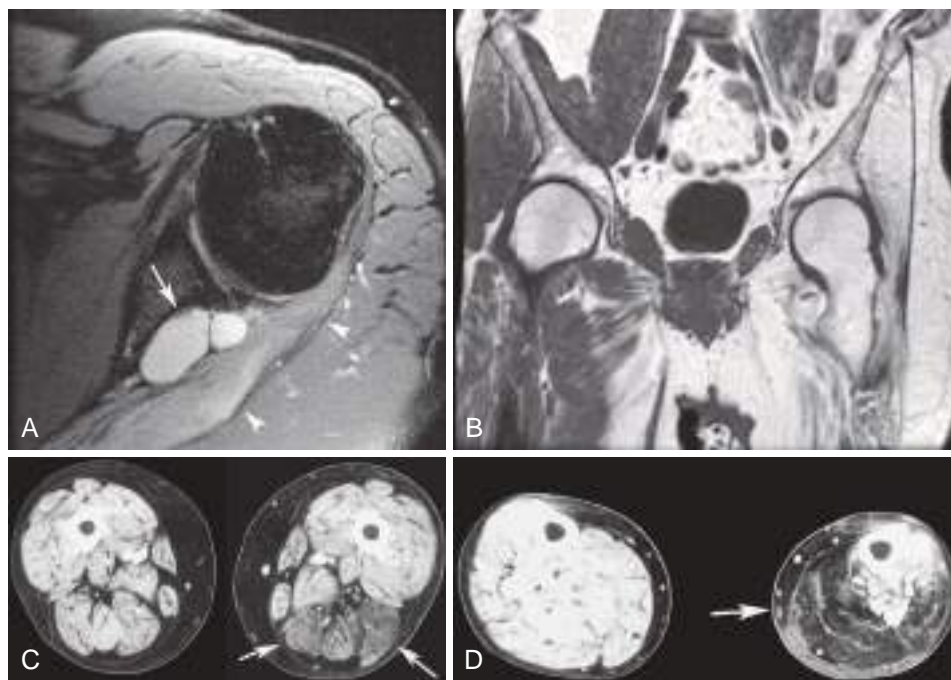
Muscle denervation. (A) Acute muscle denervation. Acute infraspinatus denervation caused by nerve compression. Axial fat-suppressed T2-weighted MR image shows diffusely increased signal intensity in the infraspinatus muscle (*arrowheads*) caused by compression of the suprascapular nerve in the scapular spinoglenoid notch by a large paralabral cyst (*arrow*). T1-weighted images (not shown) showed no fatty infiltration, indicating that the muscle injury is reversible. (B) Chronic muscle denervation, coronal T1-weighted MR image in an adult who had polio as a child shows profound fatty atrophy of left pelvic and thigh musculature. (C and D) Sciatic nerve injury. Axial CT images in the thighs (C) and calves (D) show fatty atrophy (*arrows*) of the hamstrings in C and ankle flexors in D. Fatty atrophy indicates irreversible muscle injury.
